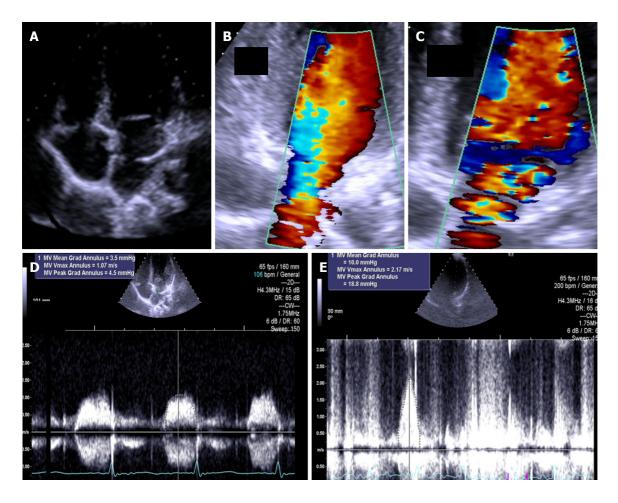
The exercise Doppler data in conjunction with the exercise data and clinical data led us to keep the patient in close clinical follow-up. A: Intraauricular septum in "cor triatriatrium"; B: Color flow before exercise; C: Color flow at peak exercise; D: CW flow before exercise; E: CW flow at peak exercise.
